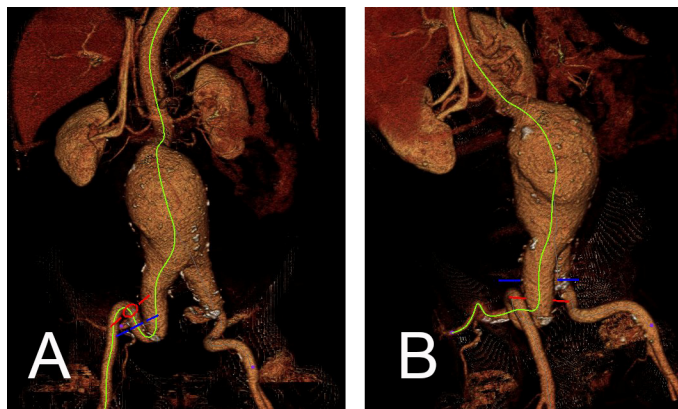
The patient with a ruptured abdominal aortic aneurysm and bilateral common iliac aneurysms with severe tortuosity in 3-D volume rendering reconstruction from the preoperative CTA. This reconstruction includes a centerline of flow to the external iliac (A) and internal iliac (B) artery. (Papper I)
